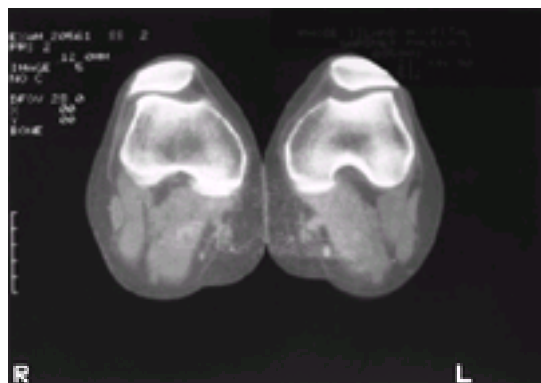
Computed tomography scan with knees in 20 degrees of flexion demonstrating chronic tilt and subluxation of patellofemoral joints.
